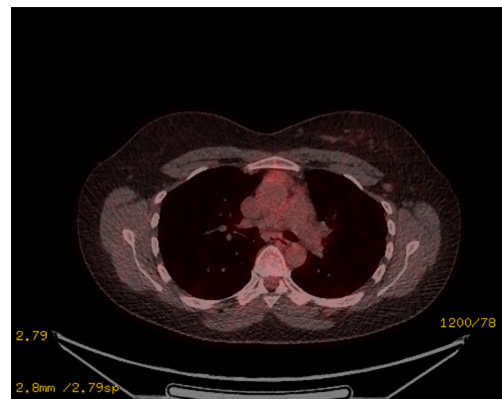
PET CT which suggested features of benign lesion. PET CT, positron emission tomography computed tomography.
